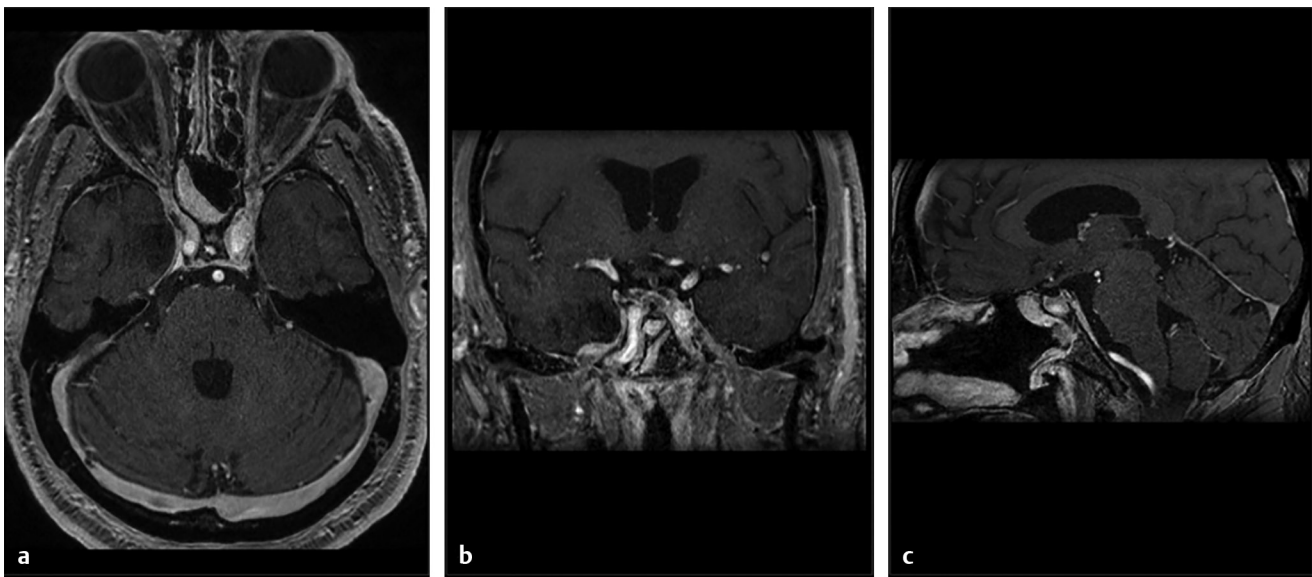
Postoperative MRI at 4-year follow-up. (a) Axial, (b) coronal, (c) sagittal view. The nasoseptal flap used for reconstruction of the defect and protection of the internal carotid artery can be seen enhancing and no signs of tumor recurrence or residual were identified.
